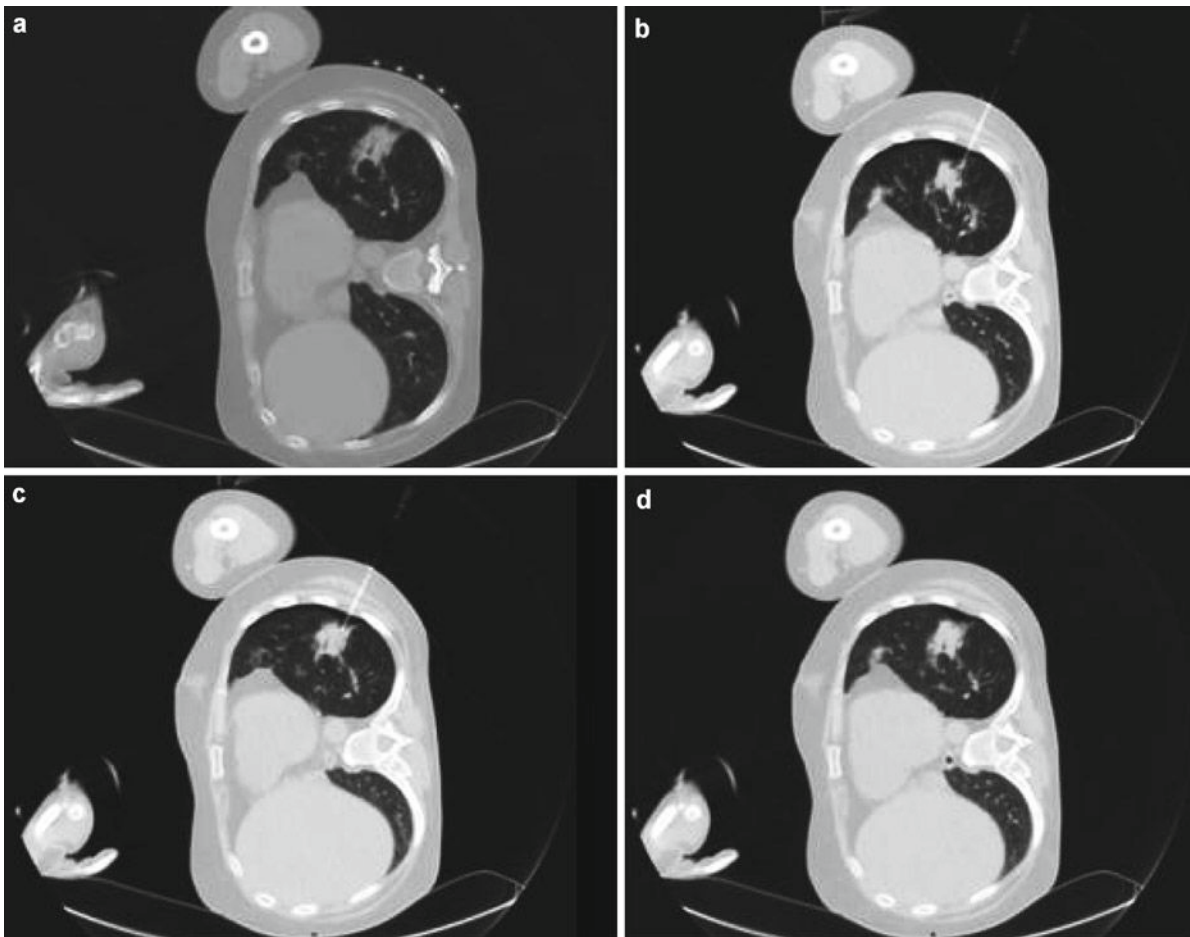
CT-guided lung biopsy in a 32-year-old patient after stem cell transplantation for acute leukemia. The target lesion is located less than 10 mm from the chest wall. A small and stable
